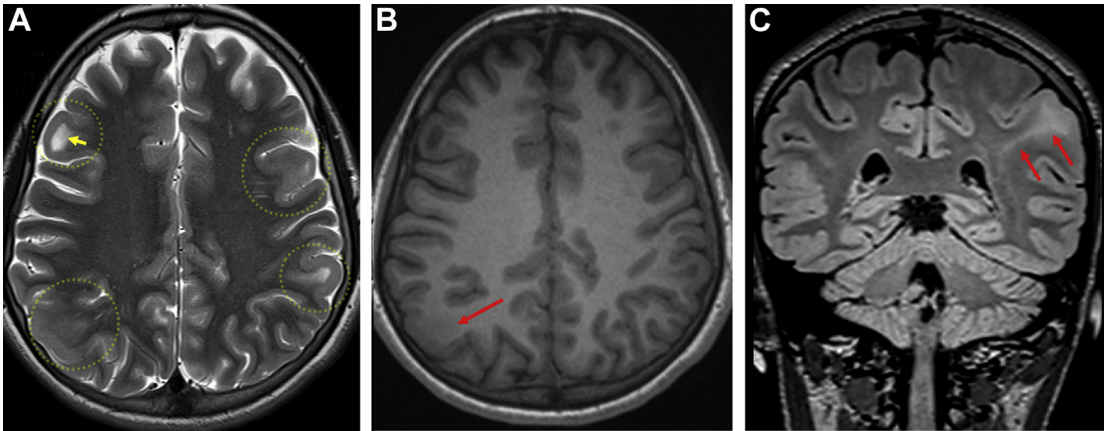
A 13-year-old girl with TS. (A) Axial T2WI and (B) T1WI show multiple cortical/subcortical mushroom-shaped tubers (dotted circles) with gray-white matter blur in right parietal tuber (red arrow). The right frontal subcortical tuber shows cystic change (yellow arrow). (C) Coronal FLAIR image shows wedge-shaped radial migration line (red arrows) extending from tuber to ventricular surface.
